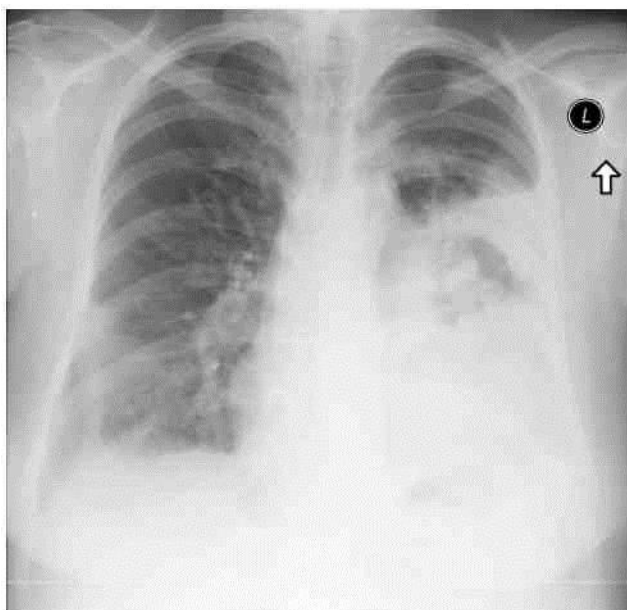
Posteroanterior chest X-ray (14/03/2013). Consolidation in the middle and lower left lung with cavity lesions in the central part and consolidation in right lung's lower lobe with effusion in both pleural cavities.
